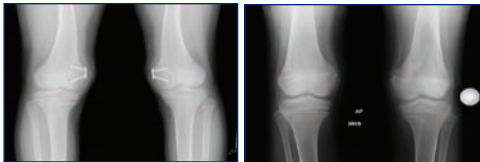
Postoperative AP radiographs of the knees showing correction of the genu valgum deformity after medial guided growth procedure using tension plate implantation.
